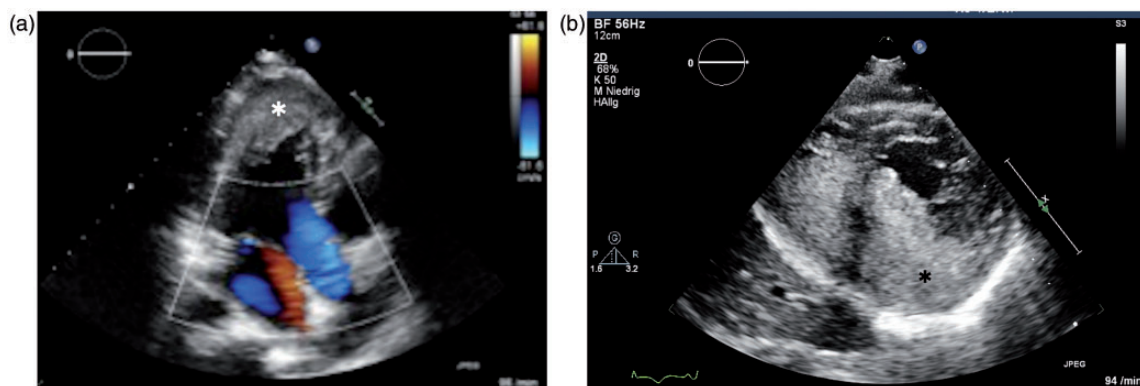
Transthoracic echocardiography four chamber view (a) and subcostal view (b) shows cardiac mass infiltrating cardiac apex, septum, and biventricular cavities (asterisks).
